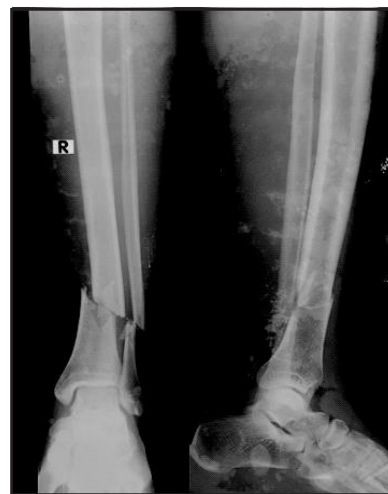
Pre-operative X-ray (Intramedullary Expert Tibial Nail)
